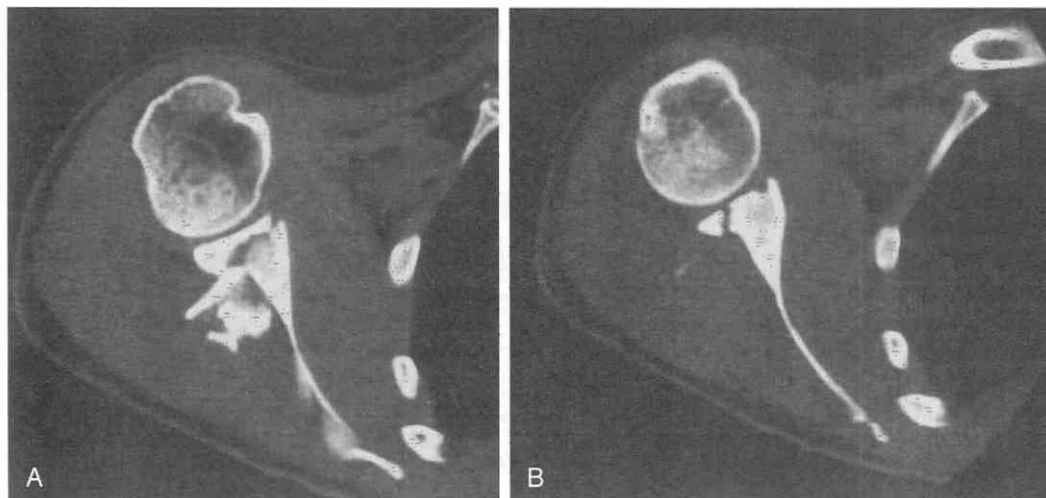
Glenoid fracture. A and B, Axial CT scans. Extension of this fracture to the articular surface of the glenoid is easily appreciated at CT.
